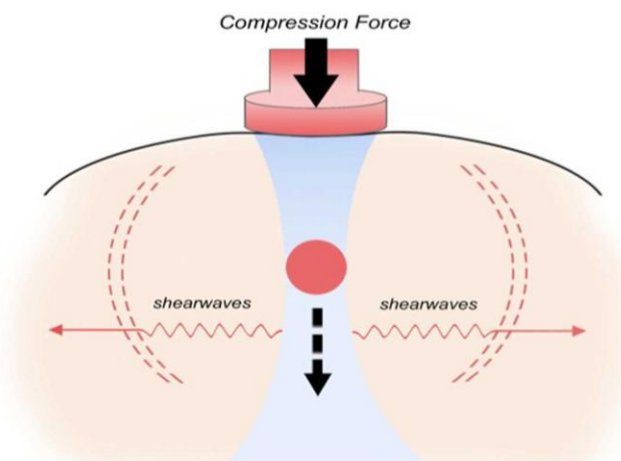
BASIC PRINCIPLE OF ELASTOSONOGRAPHY
